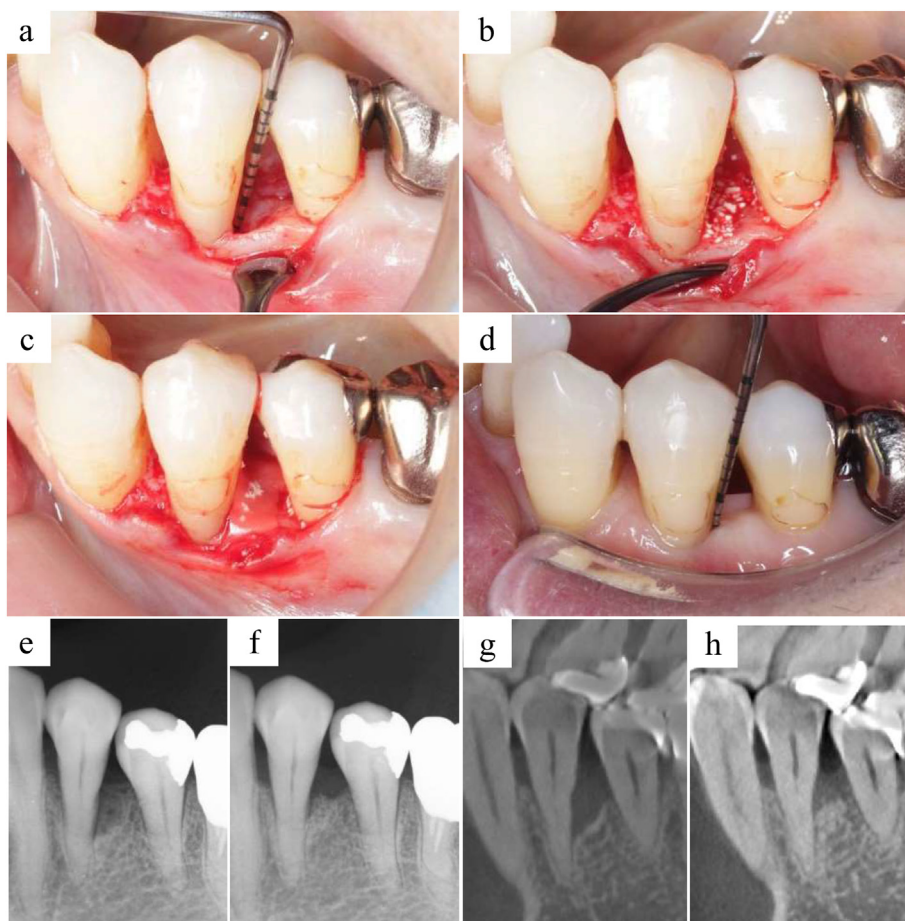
Case 1; a) 70-year-old female. a) After flap elevation of the mandibular left first premolar; #34, 1–2 wall intrabony defect was observed. b) After administration of CO₂Ap granules. c) After administration of a PLCL membrane. d) 48 weeks after the surgery. e, g) Dental x-ray image and two-dimensional section of CBCT at BL. f, h) Dental x-ray image and two-dimensional section of CBCT at 48 weeks post-surgery.
